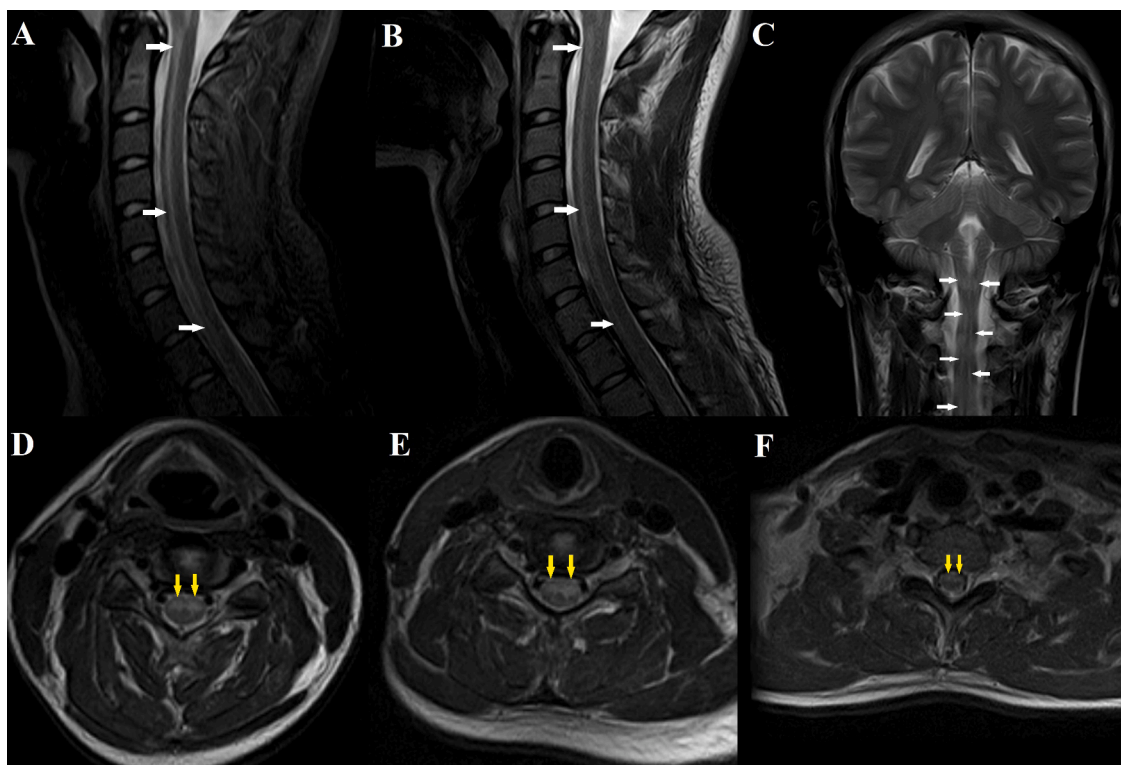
MRI of the cervical spine at admission. Sagittal STIR (A) and T2-weighted (B) images and coronal T2-weighted image (C) demonstrate longitudinal intramedullary hyperintensity within the anterior cervical spinal cord, reaching thoracic spinal cord (white arrows). Corresponding axial T2-weighted images (D–F) demonstrate the hyperintensities in the anterior horns of gray matter (yellow arrows, at level C3/C4, C5/C6 and T1/T2, respectively).
